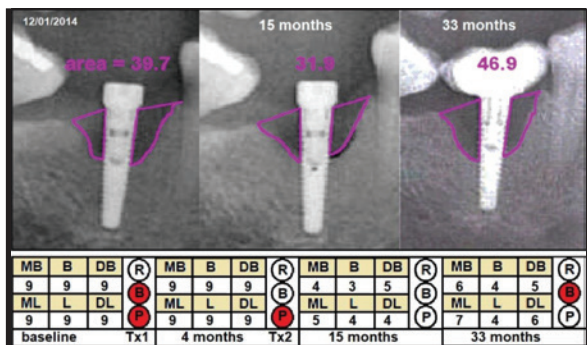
Example of a partial response to treatment (Case 2), showing changes in radiographic defect (mm²), probing depth (PD; mm) and clinical signs from baseline to 33 months later. Violet = cross-sectional area; MB = mesiobuccal PD; B = buccal PD; DB = distobuccal PD; ML = mesiolingual PD; L = lingual PD; DL = distolingual PD; R = redness; B = bleeding; P = suppuration; Tx1 = first treatment; Tx2 = second treatment.
